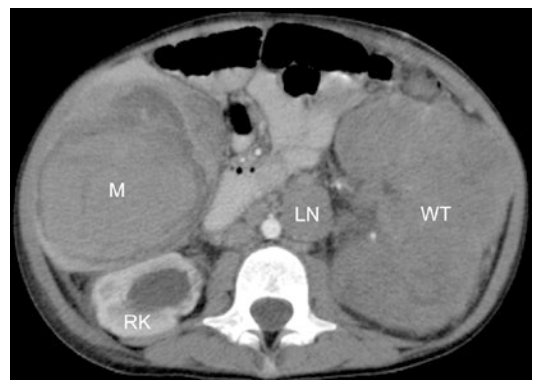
Abdominal CT scan of a 4-year-old girl with a large left-sided Wilms tumor (*WT*) measuring $10.5 \times 11 \times 17$ cm. The right kidney (*RK*) did not show any lesions. There were multiple enlarged para-aortic lymph nodes (*LN*) and liver metastases (*M*)
